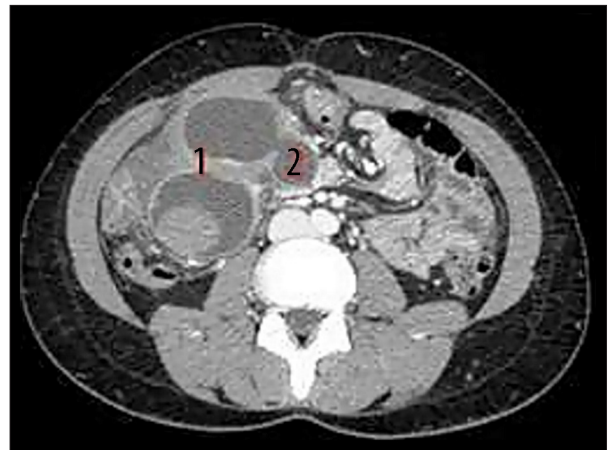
Computed tomography 2014: Antro-pyloric gastric duplication (1): Diabolo, (2): Pancreatic extension).
